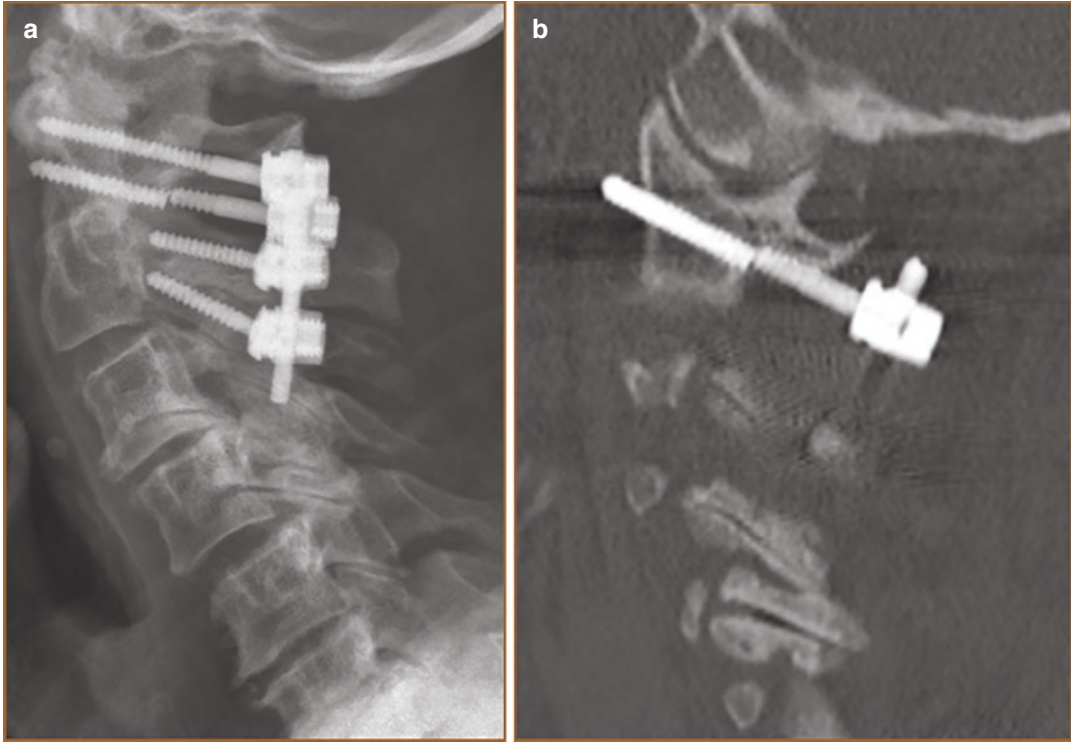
(a, b) Lateral view radiograph of the cervical spine demonstrating a fractured screw initially placed through the dens (a). Computed tomography of another patient demonstrates a fractured screw at C2 level (b)
